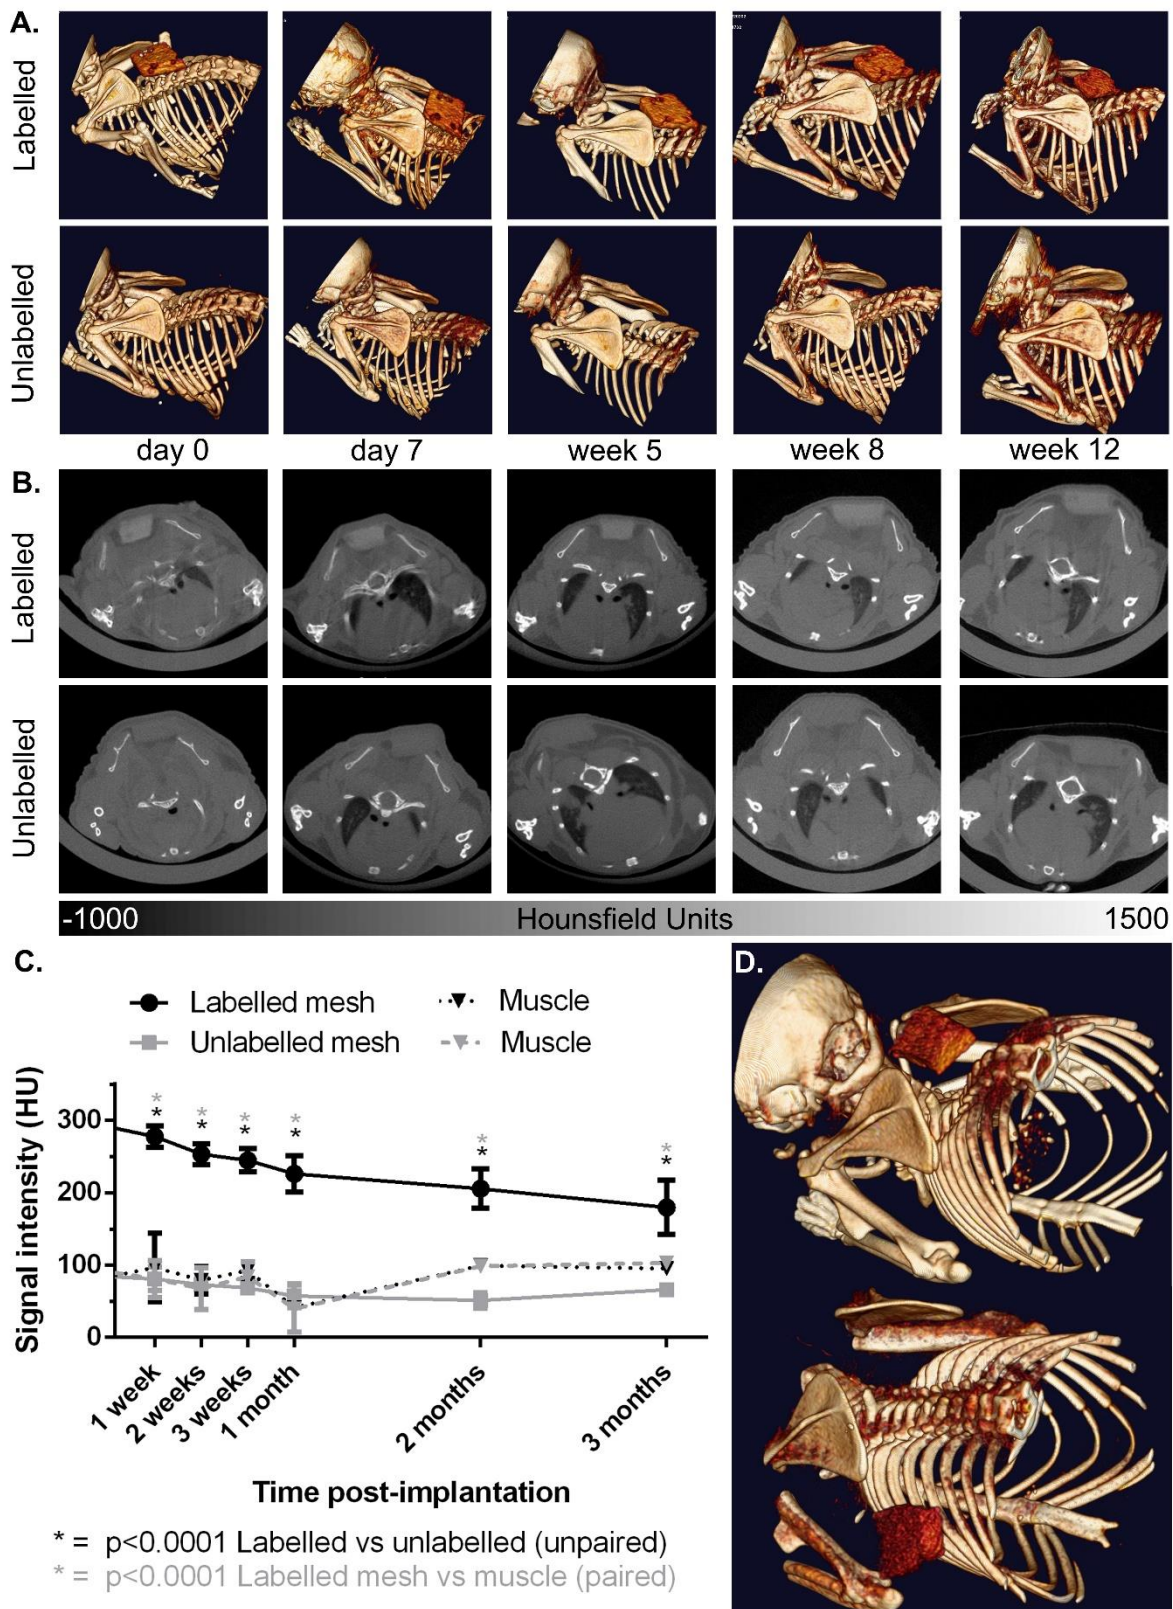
Iodinated hernia mesh samples (Xenmatrix) show increased visibility on X-ray CT vs unlabelled samples and muscle over 3 months post implantation on A. 3D reconstructions, B. axial CT cross sections, and C. region of interest quantification of x-ray absorbance (HU). Holm-Šídák multiple comparison tests show significantly higher radioopacity of labelled meshes vs muscle (paired), and vs unlabelled samples (unpaired) at all time points. $N \geq 3$ per time point, error bars show
